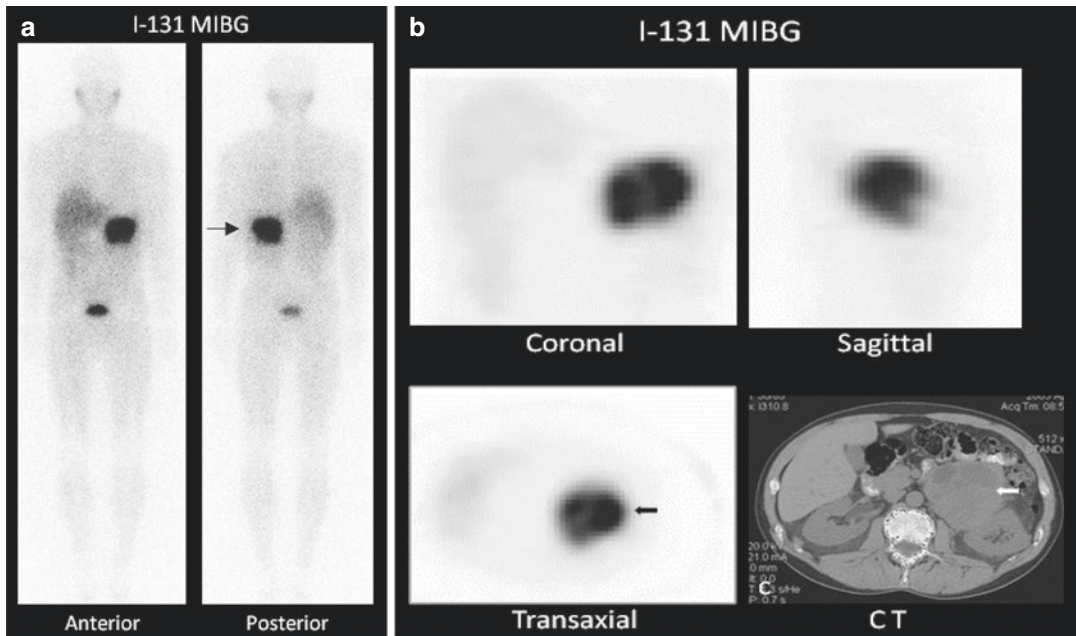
A planar (a) and SPECT (b) ^{131}I -MIBG study and a CT section of a patient with a large pheochromocytoma (arrows)
